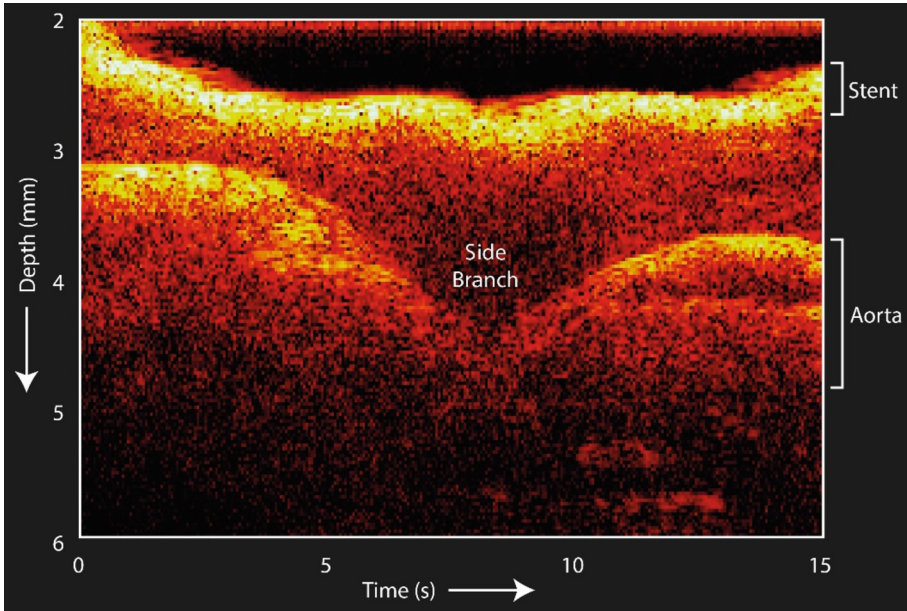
All optical ultrasound (OpUS) imaging of the endograft paired with underlying aortic tissue, performed on the benchtop. The stent endograft material was strongly hyperechoic. The underlying aorta is apparent as a 2–3 mm thick region. The side-branch presented as an absence of signal, corresponding to a discontinuity in the aortic tissue.
